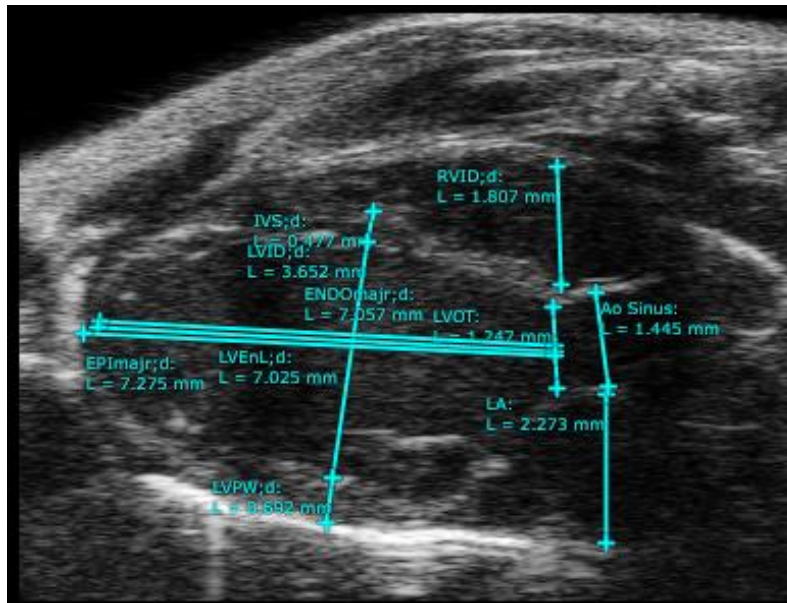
Parasternal long-axis view in Diastole with measurements of Left ventricular (LV) length, septal (IVSd) and posterior wall thickness (LVPWd) and LV internal diastolic dimension (LVIDd).
